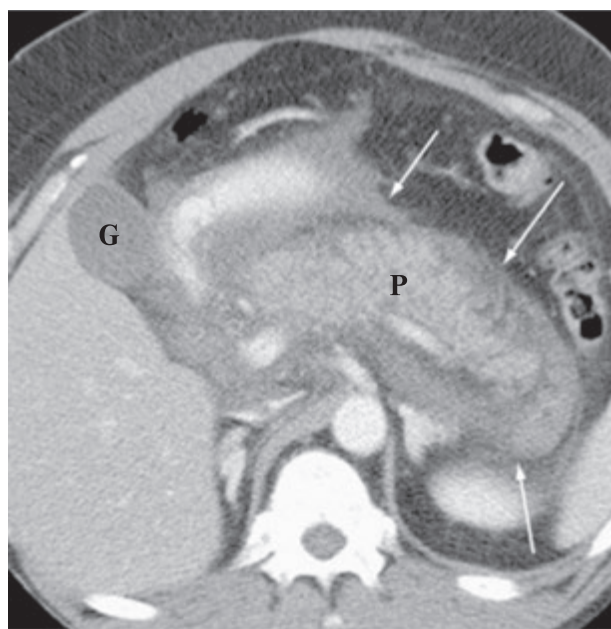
CT showing acute interstitial pancreatitis with diffuse swelling of the pancreas (white arrows): G — gallbladder; P — pancreas
